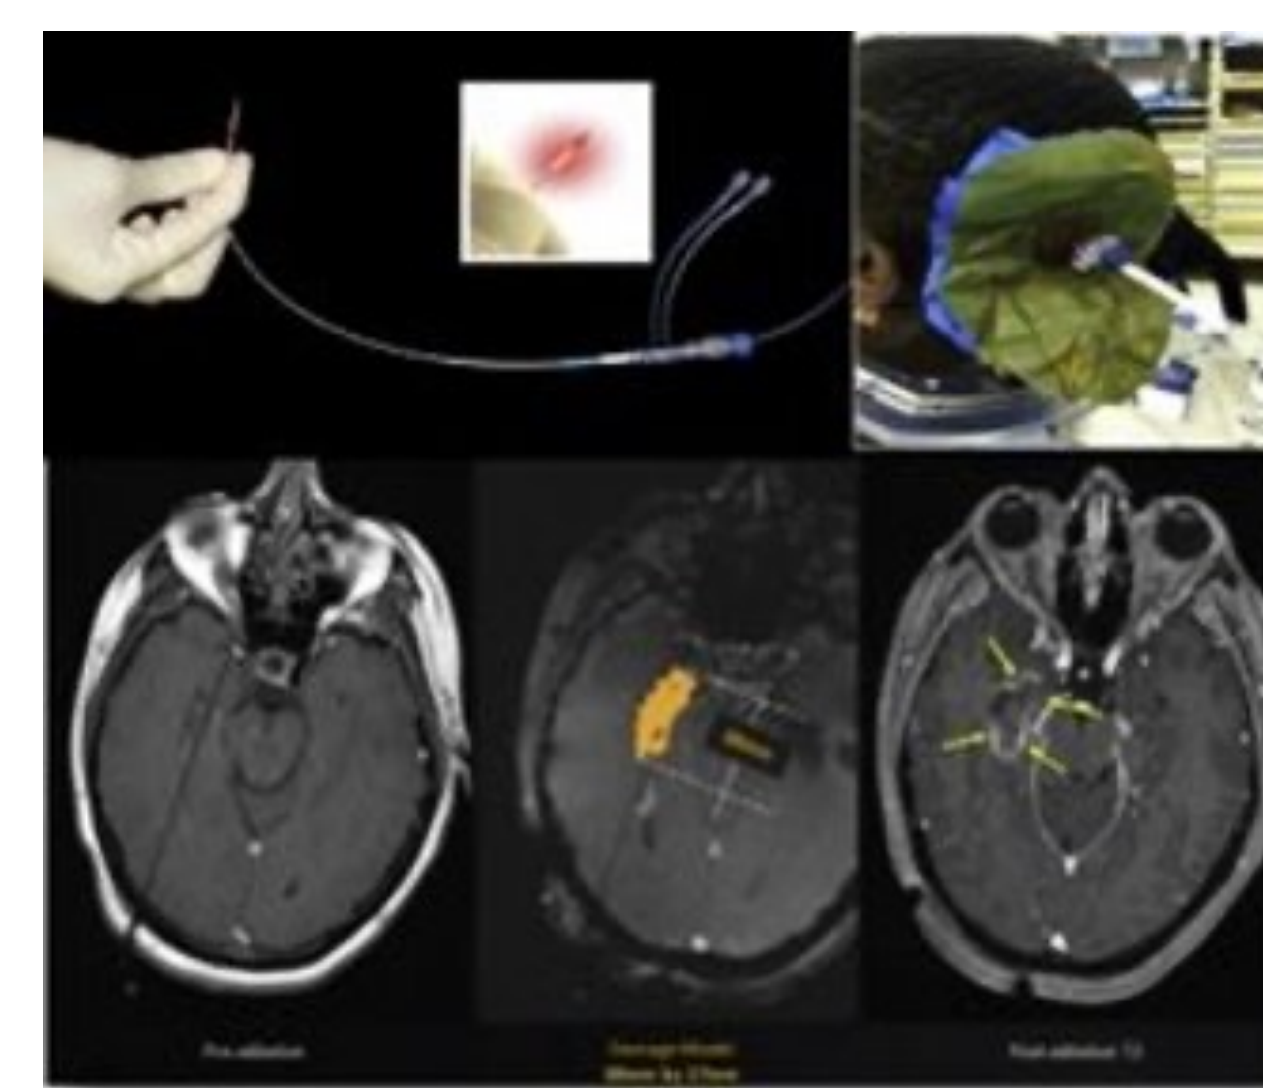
Depiction of optical fiber, ablation process, and pre-/ post-ablation MRI images in an axial plane demonstrating focal nature of damage zone (Drane, 2018, p. 2)
